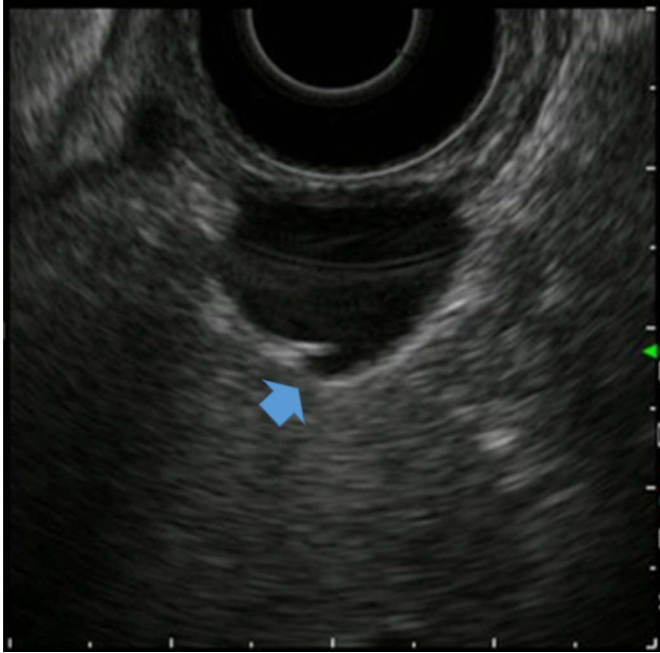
Gastric duplication cyst which is 15 × 9 mm in size with small hypoechoic nodules (arrow) was in the layer of the muscularis propria of the original gastric wall in the 12-MHz endoscopic ultrasound findings.
